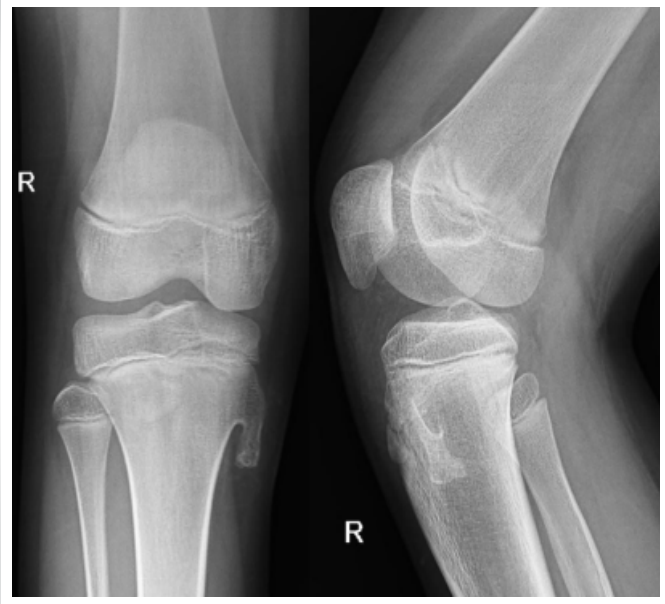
Presenting radiograph of the right knee of patient 1- anteroposterior and lateral views show an exostosis over the medial aspect of proximal tibia.
